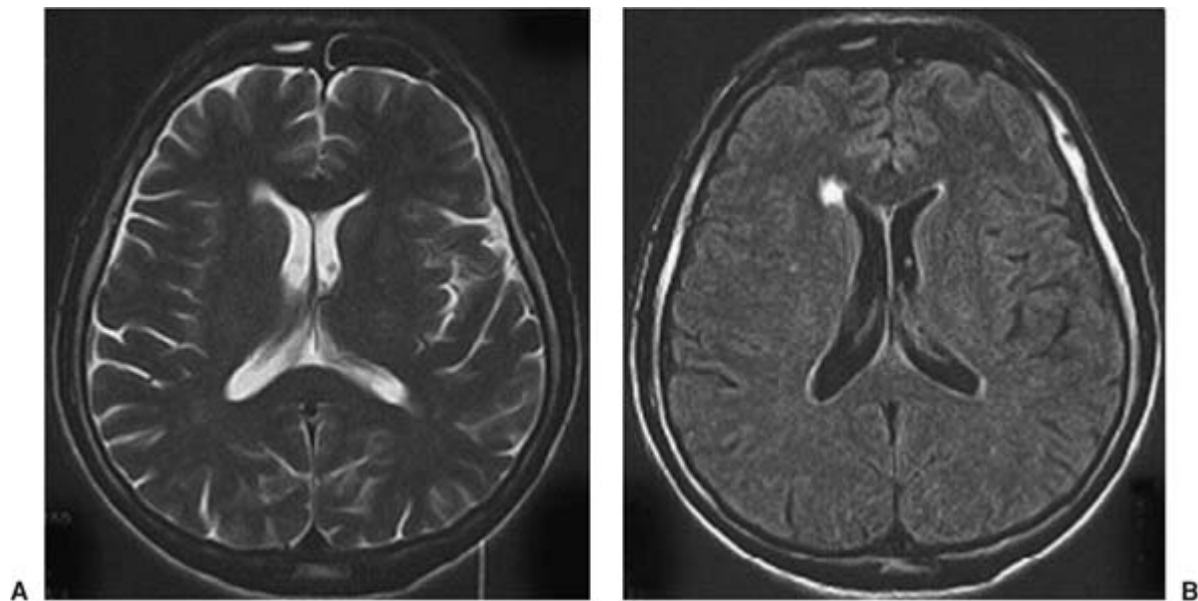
The same lesion on T2-weighted (A) and fluid-attenuated inversion recovery (FLAIR) (B) images. To the experienced eye, the lesion is easily seen on the T2-weighted images, but it is much more apparent, more easily noticed, and more confidently diagnosed with the FLAIR sequence.
